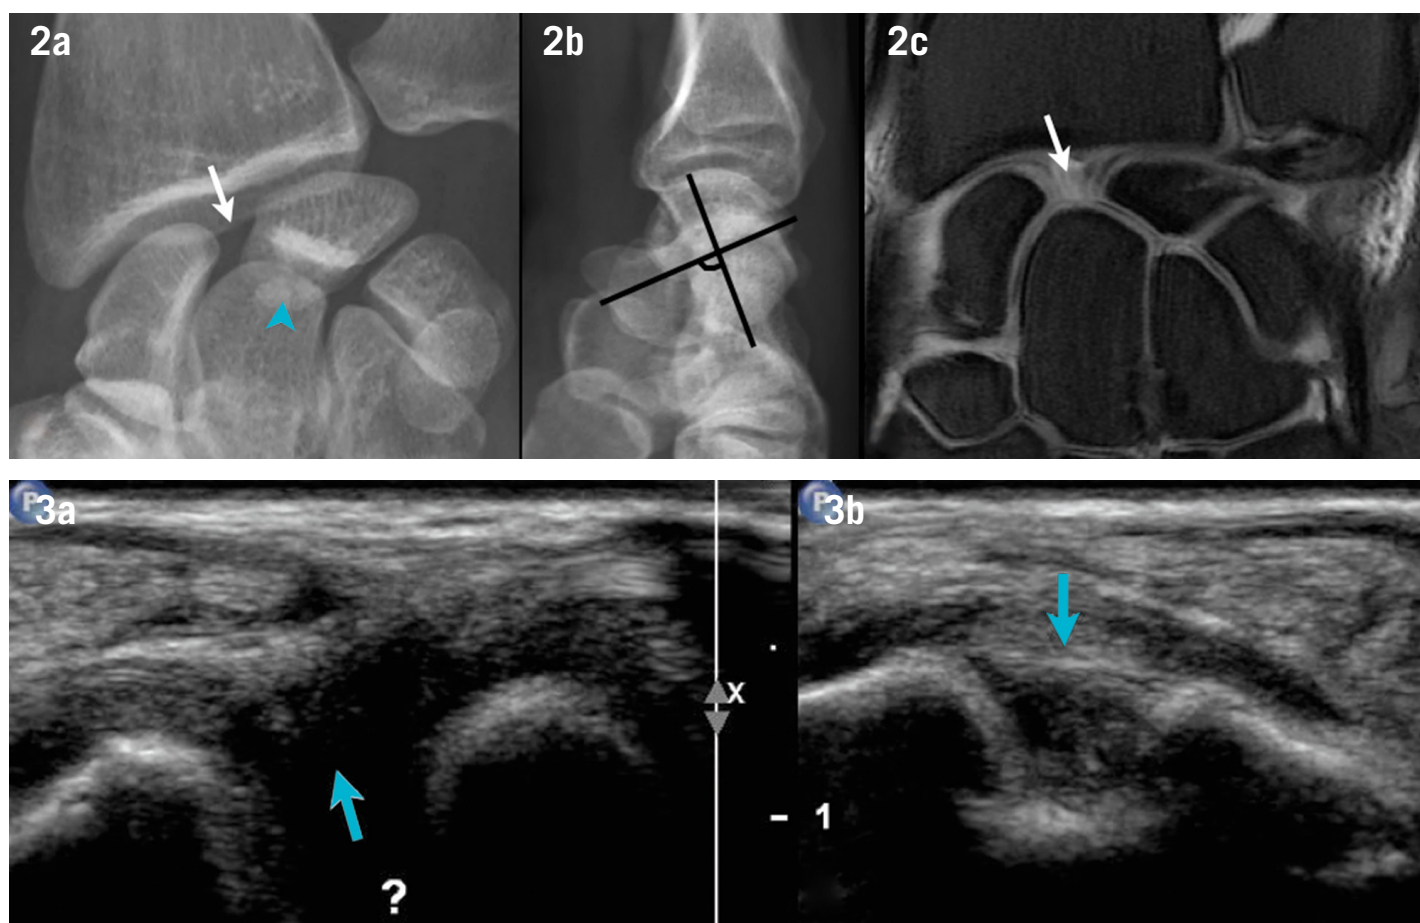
Dissociative SL instability. Anteroposterior radiograph a) shows widening of the SL joint space (white arrow) with dorsal tilt of the posterior horn of the lunate (blue arrowhead) while the lateral view b) shows an increase of the scapholunate angle. MR arthrography in coronal plane in T1-weighted sequence with fat-saturation c) shows SL tear and widening of the SL joint space. SL=scapholunate, DISI= Dorsal Intercalated Segmental Instability
